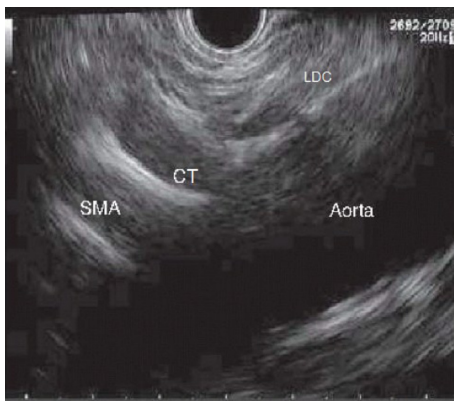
Sagittal plane of the aorta where we can see left diaphragmatic crus, celiac trunk and superior mesenteric artery emerging from Aorta. SMA: Superior mesenteric artery; LDC: Left diaphragmatic crus; CT: Celiac trunk.
